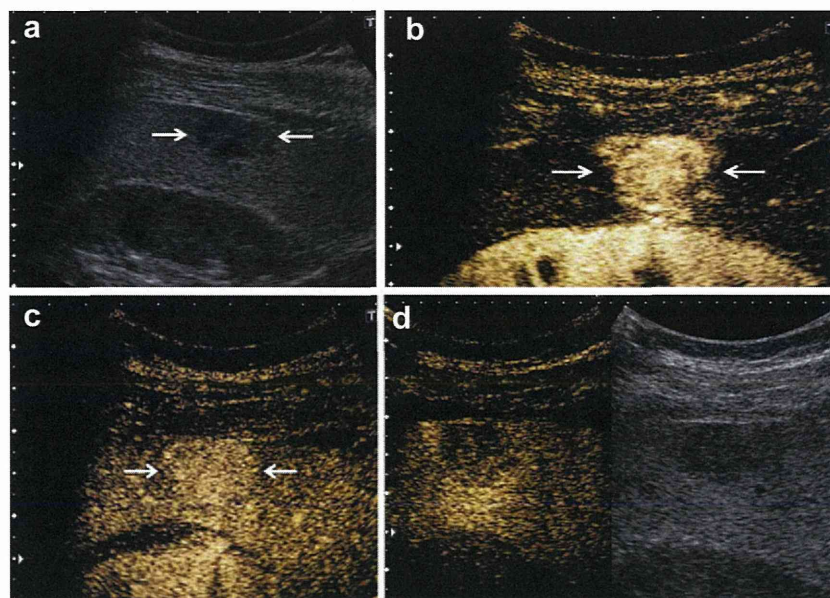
Fifty-three-year-old man with normal liver function and a high-flow hemangioma in segment 6. (a) B-Mode ultrasound image reveals a hypo-echoic mass (lesion diameter = 10 mm) (arrows). (b) Vascular-phase image reveals homogeneous arterial enhancement of the lesion (arrows). (c) Late vascular-phase image reveals a slightly hyper-echoic lesion compared with adjacent liver parenchyma (arrows). (d) Kupffer-phase contrast image (10 min after injection) and anatomic B-mode image displayed side-by-side reveal a slightly hypo-echoic lesion compared with adjacent liver parenchyma.
